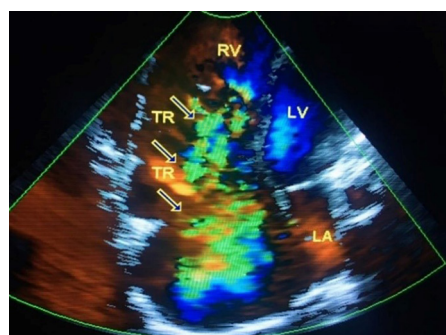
Color Doppler echocardiography Apical 4 chamber view revealed Tricuspid regurgitation
